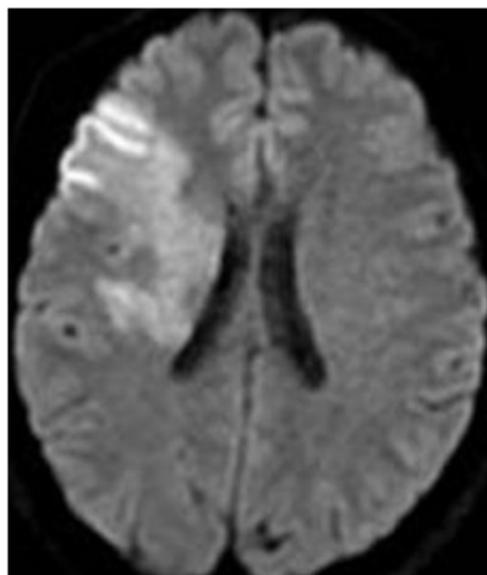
MRI of brain showing infarct in right fronto-parietal lobe
